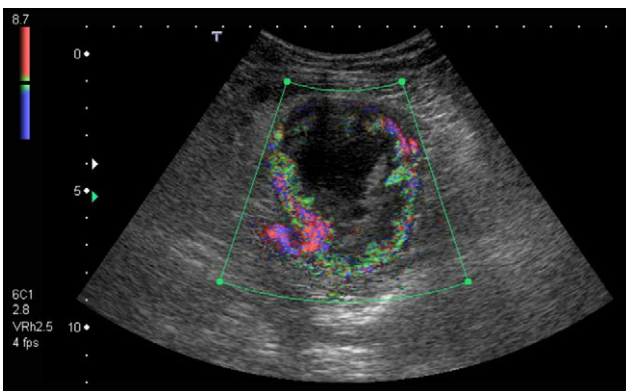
Power Doppler showing anarchic vascularisation (stenoses, anastomoses, “unbalanced” vascular branches) fitting a picture of an aggressive lesion.
